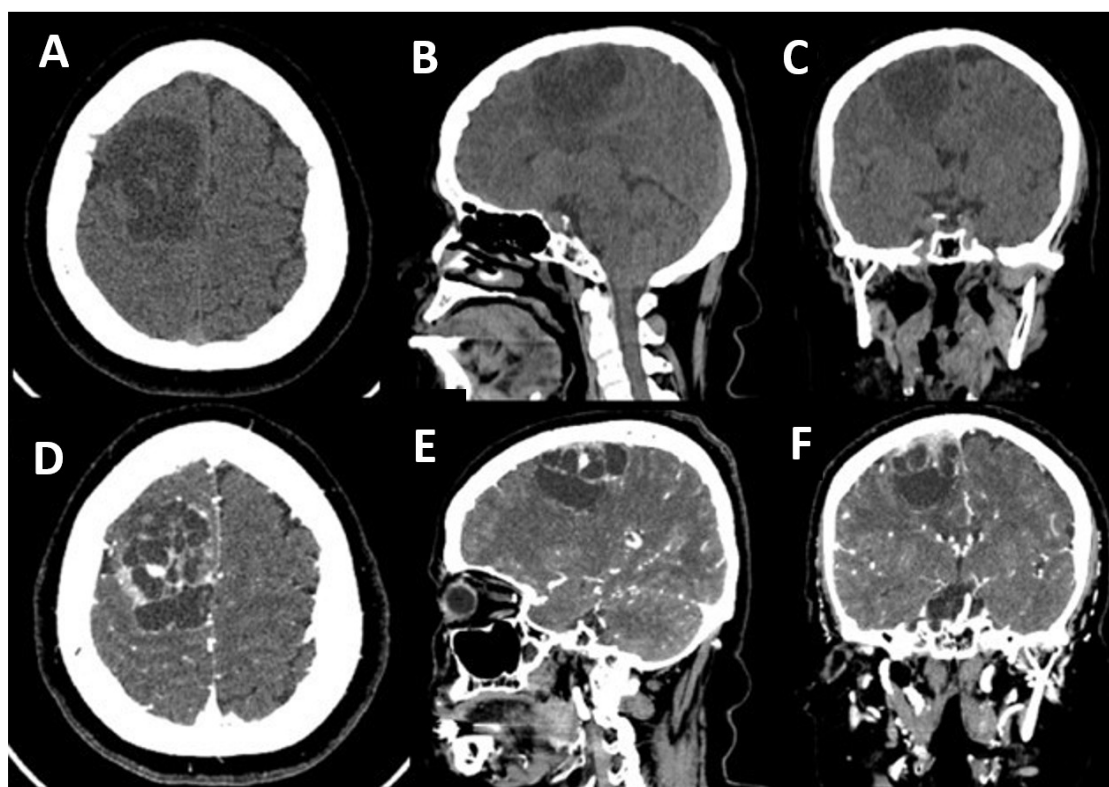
Non-contrasted CT scan in axial (A), sagittal (B), and coronal (C) views. A heterogeneous extra-axial broad-based cystic lesion is identified in the frontal convexity, causing displacement of the adjacent parenchyma. Contrast-enhanced CT scan, in axial (D), sagittal (E), and coronal (F) views, shows intense enhancement of the septa and the solid components, with a broad implantation base adjacent to the *falx cerebri*.
